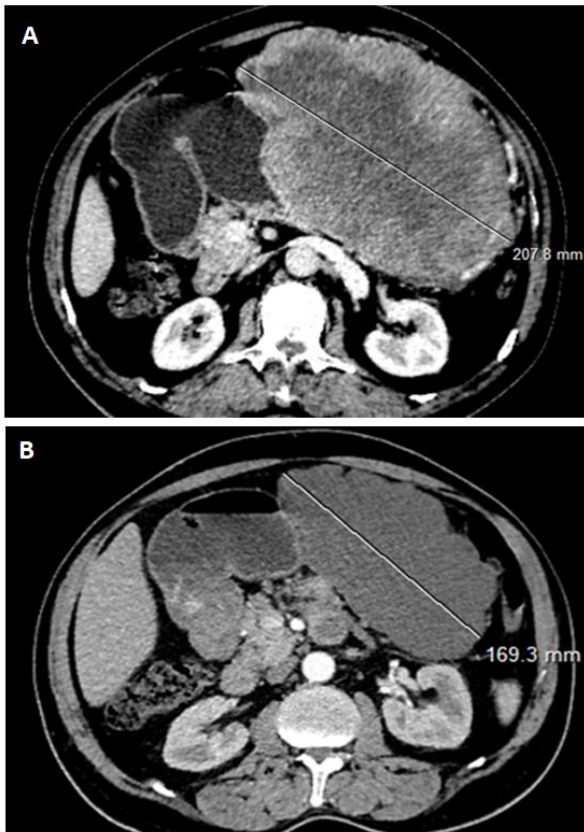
Abdominal CT scan in axial slices after injection of contrast product, in the portal phase, before (A) and 6 months after Imatinib (B), shows: in the image (A) a voluminous tumor mass with exophytic development from the greater curvature of the stomach, with two components: peripheral fleshy and central necrotic. Image (B) shows a regression in size of the tumor mass, which has become completely necrotic
